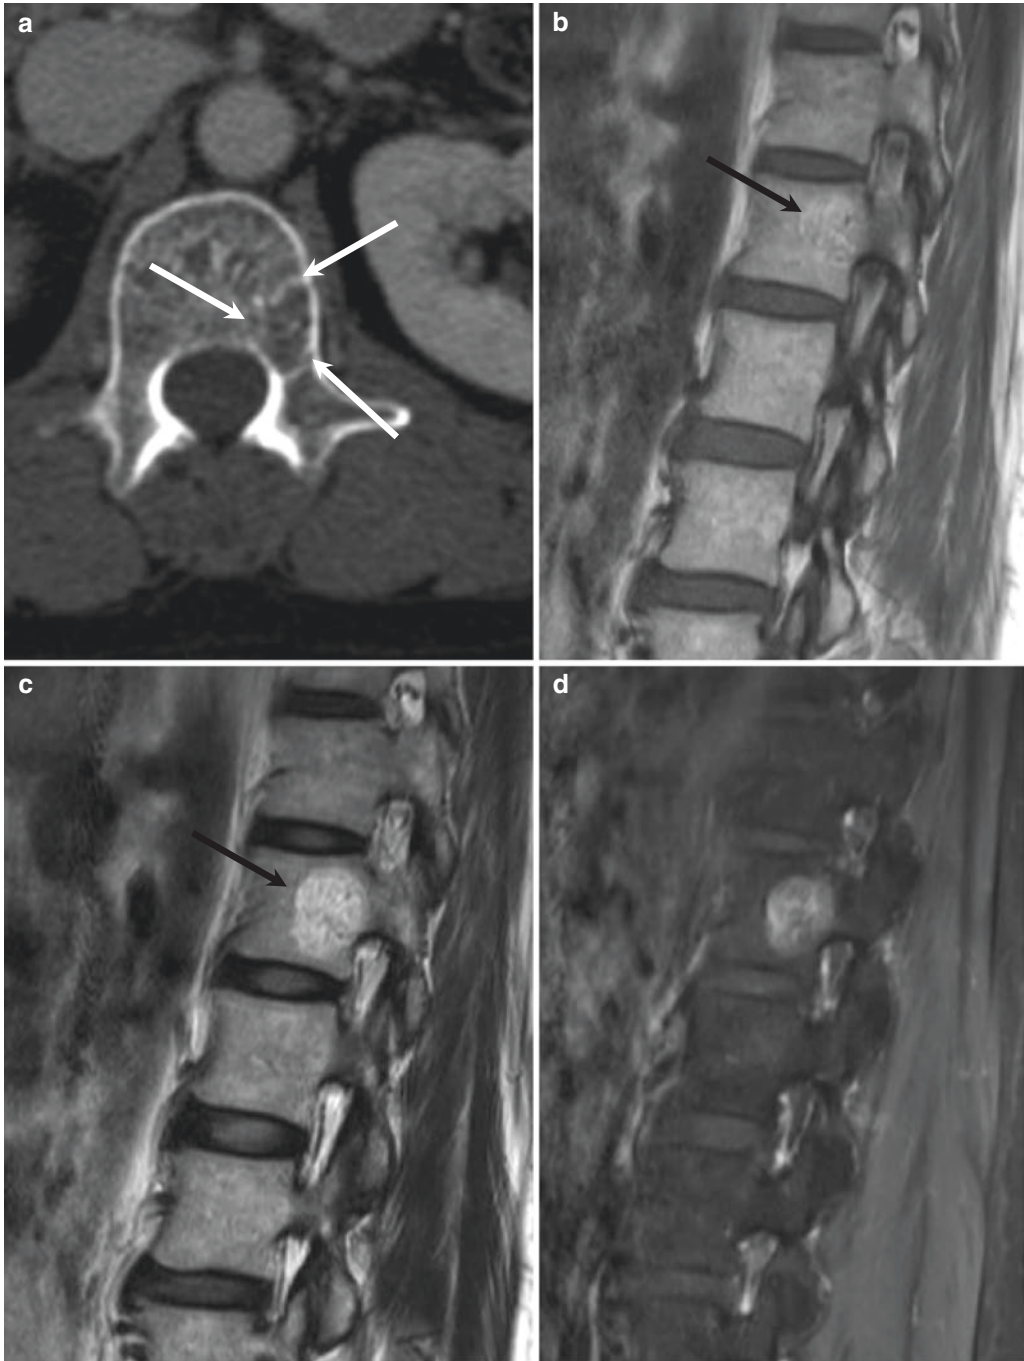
Hemangioma at L1 vertebra in a 57-year-old woman. Axial CT scan of lumbar spine (a) shows an osteolytic lesion in the left posterior corner of the vertebral body with internal dot-like trabeculation (white arrows). T1-weighted sagittal
